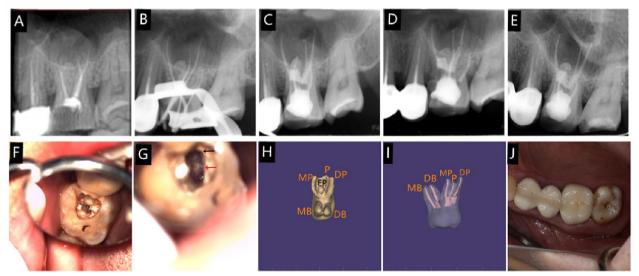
A A preoperative periapical radiograph of tooth #26; B The master apical cone periapical radiographs; C The obturation periapical radiograph; D Three-month follow-up; E Six-month follow-up; F Pulp cavity after removing filling material: G Pulp cavity after removing mesial roof of the pulp chamber; black arrow represents the mesio-palatal canal orifice;red arrow represents the palatal canal orifice. H-I The 3D reconstruction of tooth #26 showing three roots (one C-shaped palatal root, one MB root and one DB root) and an EP; J Crown over tooth #26
